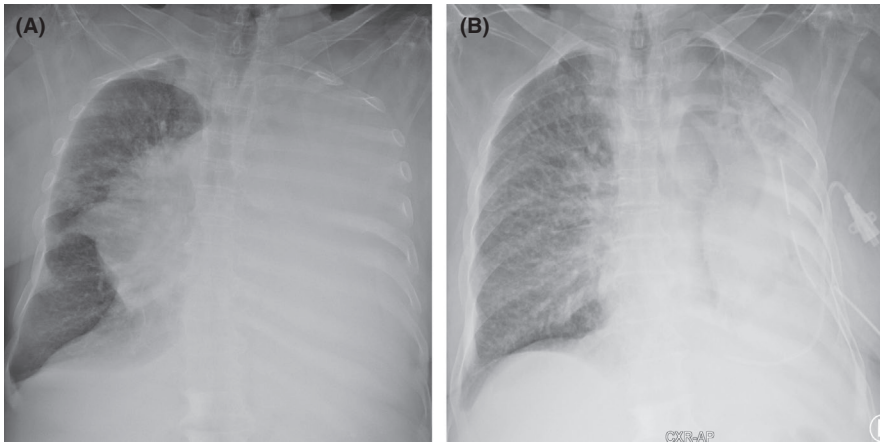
Chest x-ray shows A, complete left lung consolidation and B, control chest x-ray post pleural and pericardial fluid drainage
